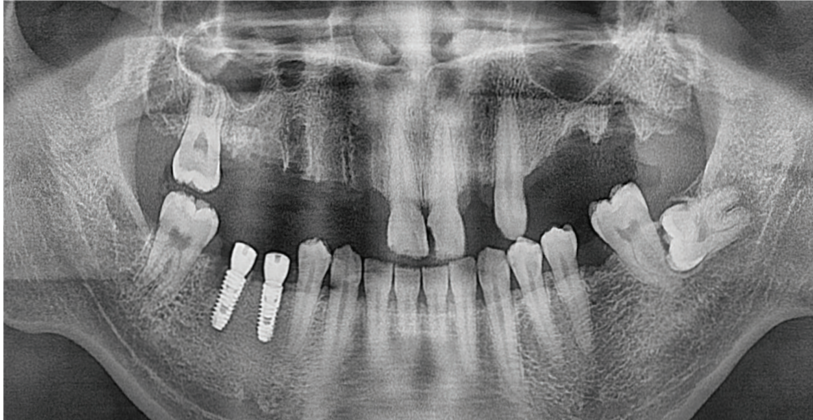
Post op panoramic X-ray view
